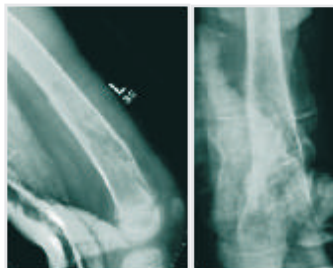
X-ray 4 weeks later – lytic lesion visible
